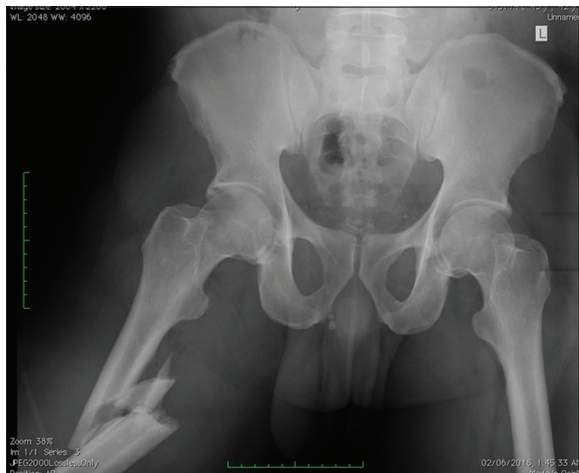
X-ray showing the right femoral shaft fracture
